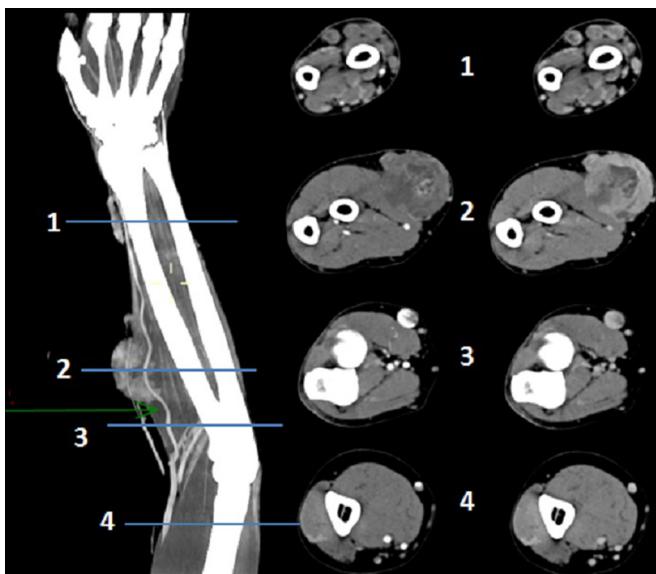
CT scan, where different axial sections are shown, the presence of mass following superficial venous paths corresponding with the cephalic vein in the left forearm. The green arrow indicates the path of the radial artery.
